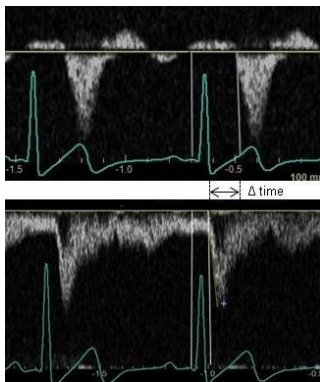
PW Doppler signal at the femoral artery (upper part) and the common carotid artery (lower part). At both signals, the time interval is measured between the onset of the QRS complex and the onset of the systolic PW Doppler signal. Δtime is calculated as the difference between both time intervals.
